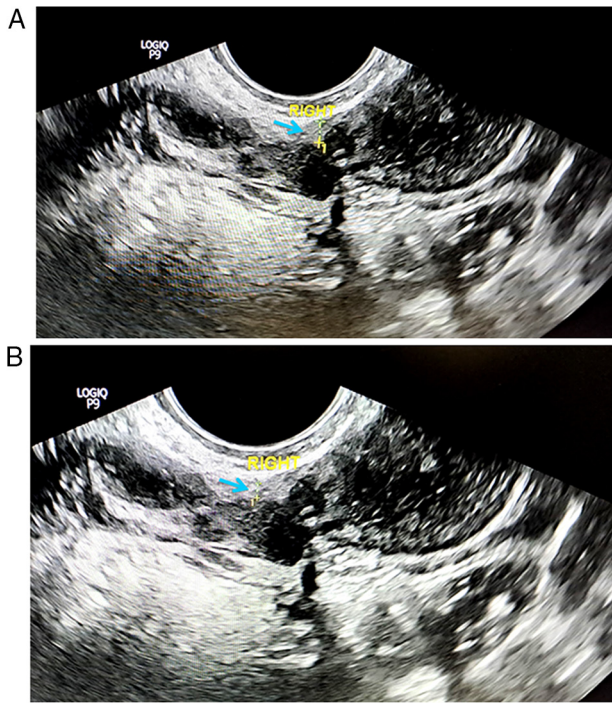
(A and B) Transvaginal ultrasonography demonstrating an eccentrically located interstitial gestational sac with asymmetric thinning of the surrounding myometrial mantle (<5 mm; blue arrow) and absence of surrounding endometrium. (A) Myometrial thickness, 0.34 cm. (B) Myometrial thickness, 0.21 cm.
